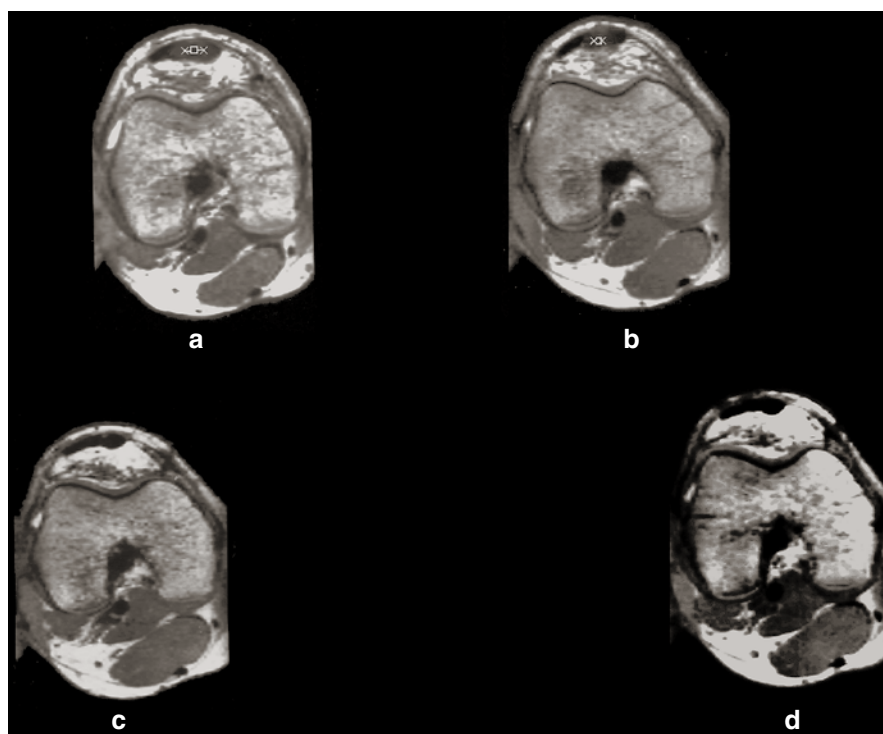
(a–d) The serial MRI examinations demonstrate that the donor-site gap was 7 mm at 6 weeks, 2 mm at 6 months and completely healed at 27 and 6 years. Furthermore, the thickness of the patellar tendon decreased over time. This is a male patient who, at the time of the index operation, was 18 years old (Copyright Jüri Kartus, published with permission)
